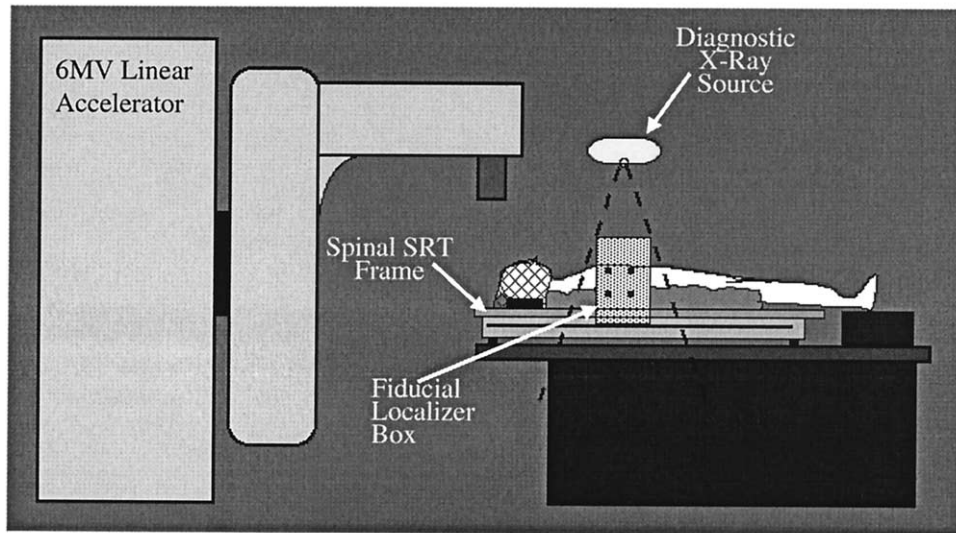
SSRT LINAC setup. Anterior and lateral radiographs are exposed, using a standard mobile radiographic unit in the LINAC room.
